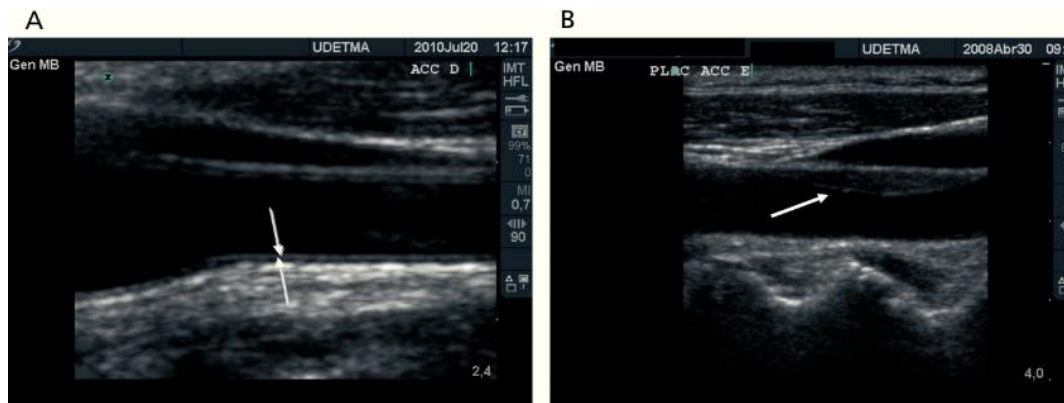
Ultrasound image of carotid arteries* (Betriu-Bars and Fernández-Giráldez, 2012). A: View of the arterial wall for measuring the CIMT at the level of the common carotid artery. Arrows delimit the CIMT. B: Plaque along the anterior wall of the common carotid artery.
